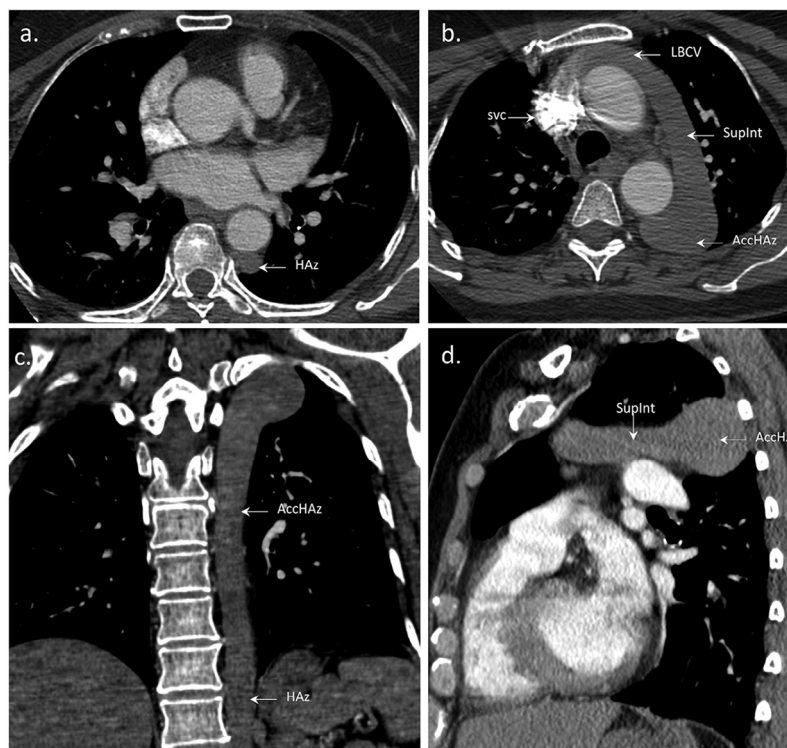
Axial computed tomography pulmonary angiography (A, B), coronal oblique (C) and sagittal (D) reformations demonstrate HAZ-AccHAz continuation of the left IVC, draining into the dilated SupInt, which in turn drains into the LBCV and then into the normal right-sided SVC. AccHAz, accessory hemiazygous; HAZ, hemiazygous; IVC, inferior vena cava; LBCV, left brachiocephalic vein; SupInt, superior intercostal vein; SVC, superior vena cava.
